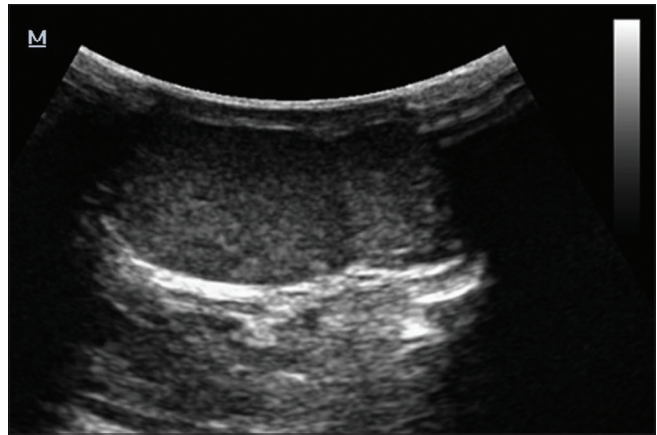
Ultrasound demonstrates a right bilobed testicle
